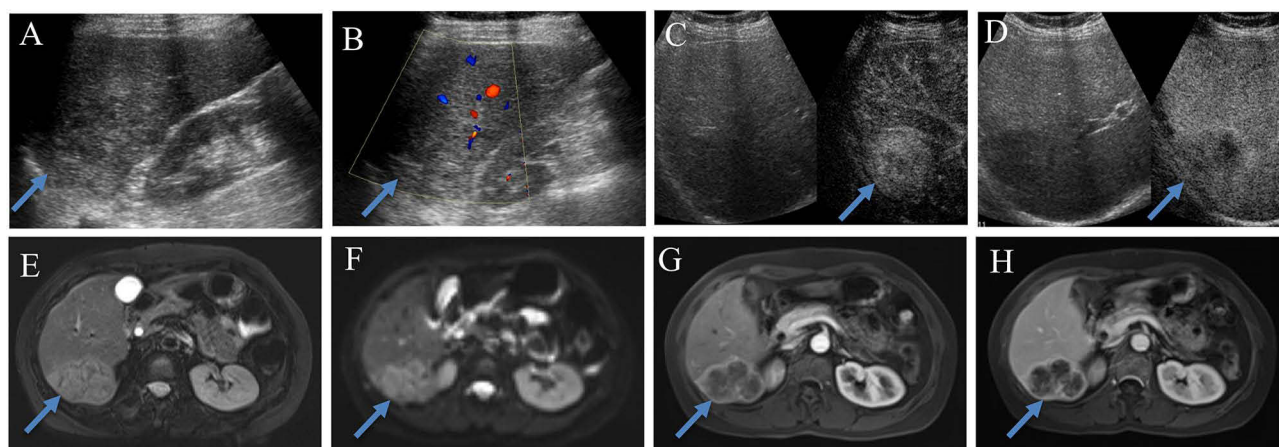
A 51-year-old woman with DPHCC in the right posterior lobe, and the mass was indicated by the blue arrow. (A) Grayscale ultrasound showed a hypoechoic, heterogeneous and irregular tumor. (B) Color Doppler imaging showed a grade I blood flow. (C) The arterial phase of CEUS showed uneven hyper-enhancement and non-enhancing area. (D) The delayed phase showed low enhancement and non-enhancing area. (E) T2-weighted image showed a moderately high signal mass with slightly higher signal margins. (F) Diffusion-weighted image ($b = 500$) showed a high signal ring in the periphery of the mass and a slightly higher signal in the center. (G) The arterial phase showed rim-APHE. (H) The portal venous phase showed mild decreased enhancement.
